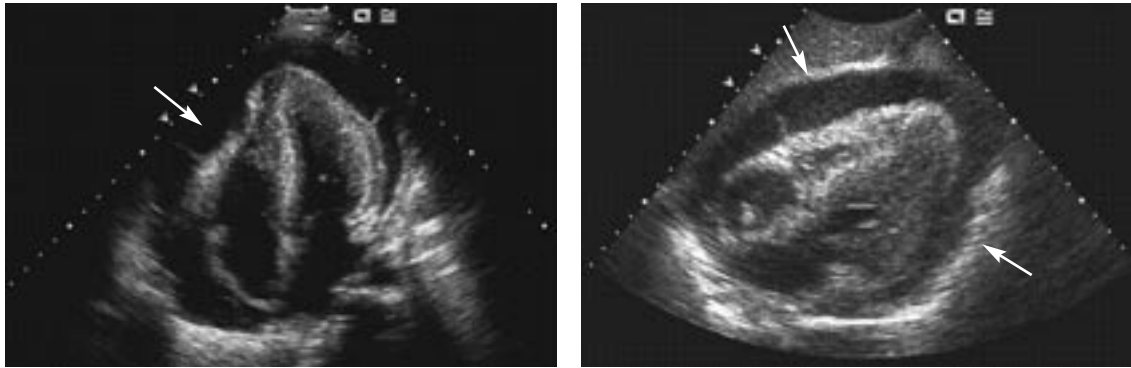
Echocardiographic four-chamber views show fluid in the pericardial space compressing the cardiac chambers.
